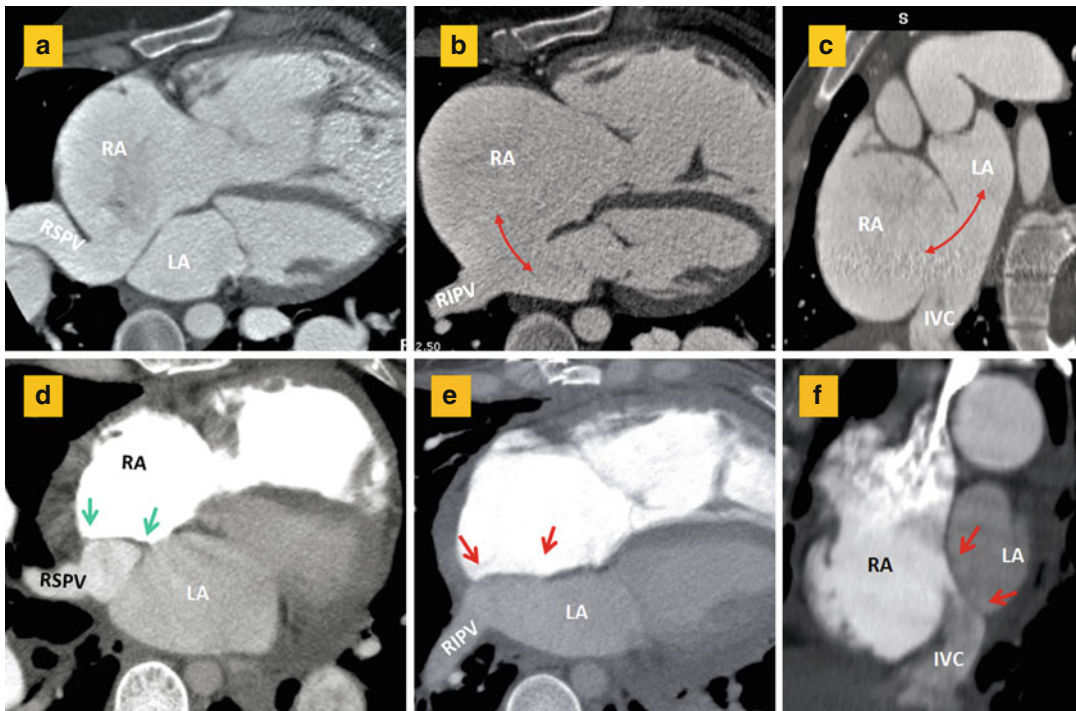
(a–c) CT images before surgery show anomalous drainage of the right superior pulmonary vein (RSPV) into the right atrium (RA) in association with a large atrial septal defect (double-headed arrows) involving inferior aspect of the interatrial septum. Short axis image (c) shows large inferior septal defect and overriding of the inferior vena cava (IVC) over both atria making it difficult
